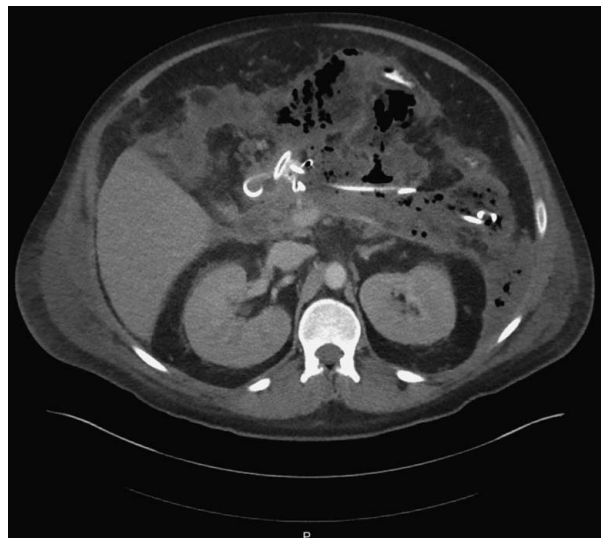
Computed tomography abdomen of the collection after drainage.
